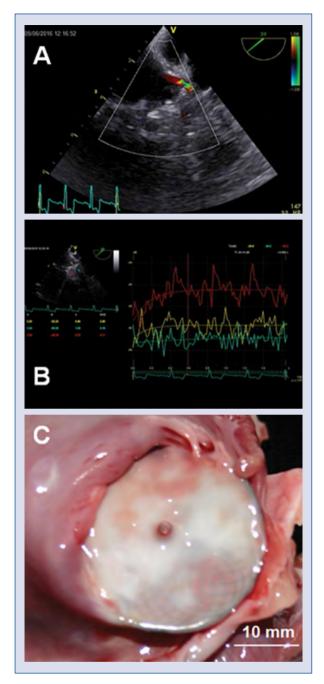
Example of contrast-enhanced transesophageal echocardiography (cTEE)-score 2 (3-months post--left atrial appendage closure [LAAC]); A. Color Doppler flow imaging (CDFI): a width of 2 mm peri-device flow into left atrial appendage (LAA); B. cTEE and time intensity curves (TIC): microbubbles got into LAA through a communication channel quickly from left atrium (LA) to LAA after LAAC, the TIC in LAA (red) was higher than the one in LA (yellow) due to the effect of an echo by the cover-plate; C. Gross examination: fully neo-intimal coverage of occluder's atrial-surface, the left edge of cover-plate was inside LAA, and an irregular fissure along the cover-plate's edge was found and passed with a 18-gauge hypodermic needle from LA to LAA.
